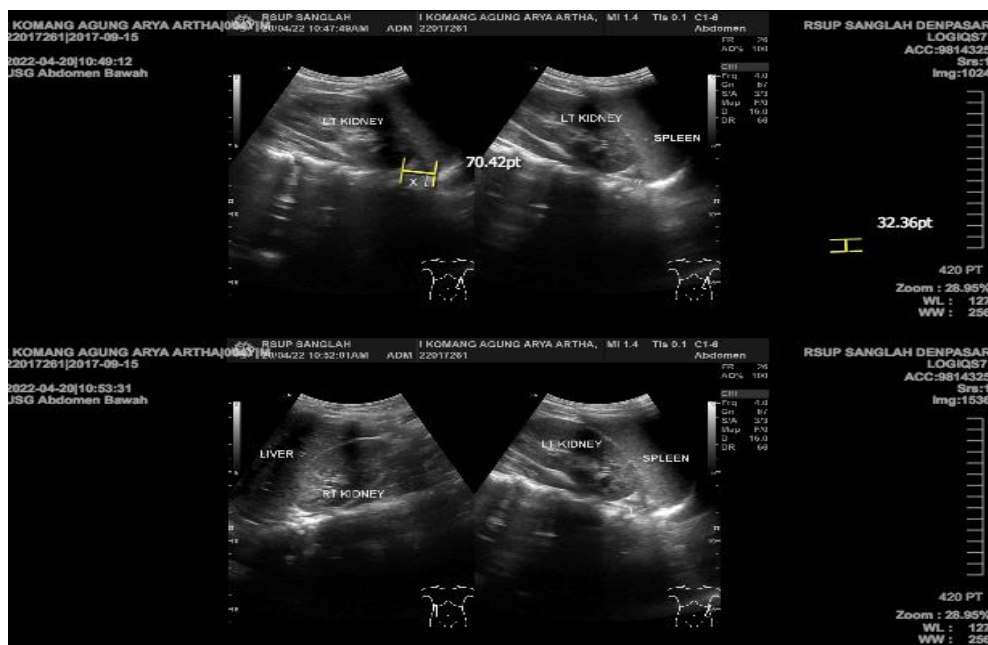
Upper abdomen ultrasound revealed a picture of hyperplasia of left adrenal gland
